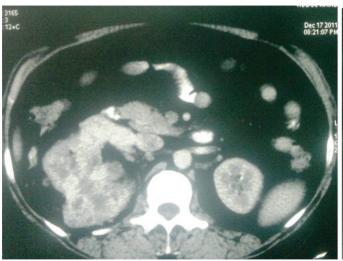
Computed tomography scan of the abdomen of the same patient showed an ill-defined, heterogeneous upper polar renal mass ( $10 \times 8 \times 7$  cm).
